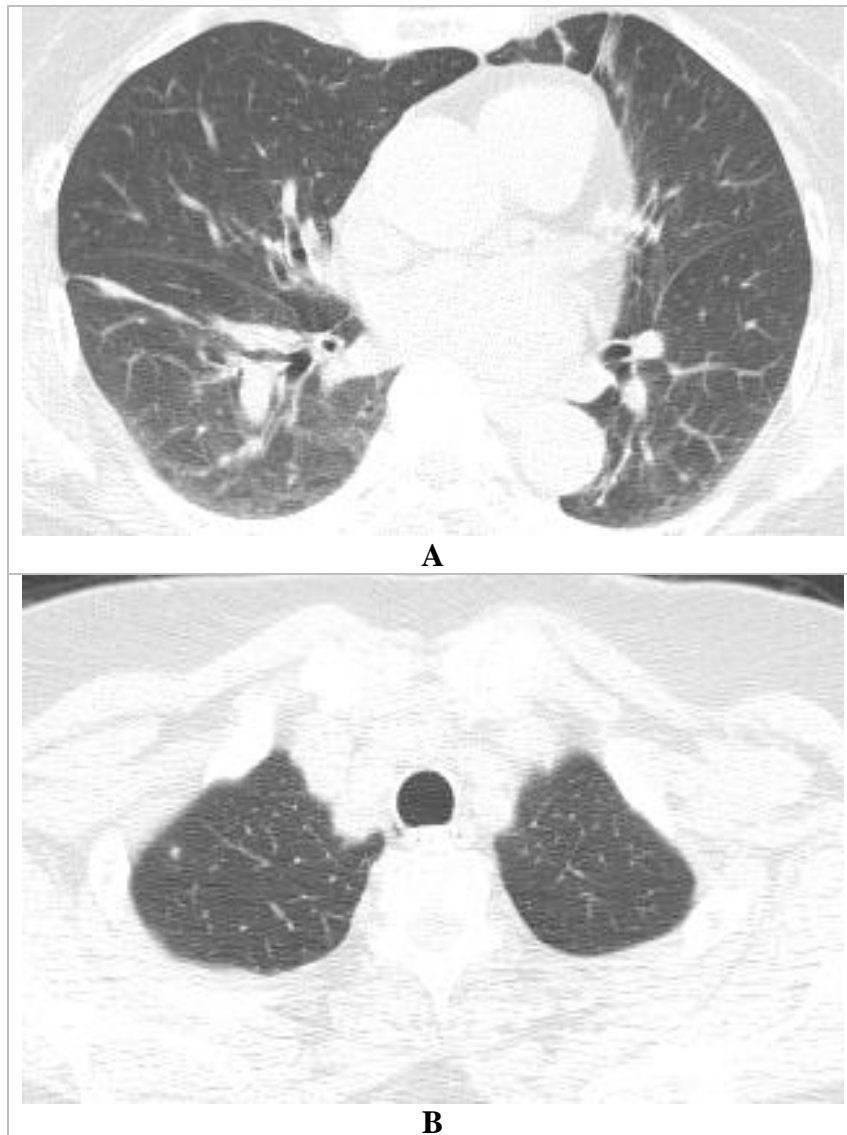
Chest computed tomography (CT) findings of patient No.1 in whom rare NTM of *M. conceptionense* were isolated twice.
